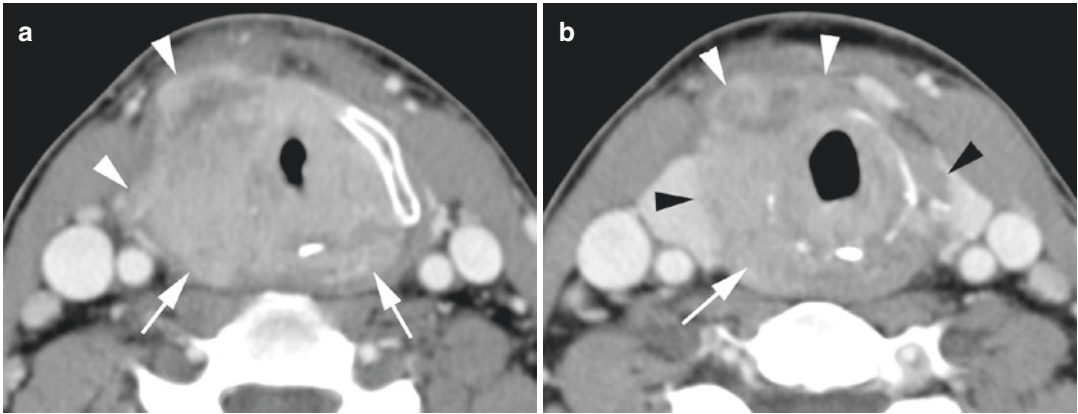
Axial contrast-enhanced CT images in a patient with extensive glottic squamous cell carcinoma. (a) Level of true vocal cords. Circumferential neoplastic involvement of the glottis, with massive destruction of the thyroid cartilage and extralaryngeal spread into the soft tissue anterolateral to the larynx (white arrowheads). Posterior tumor spread into the hypopharynx is at this level visible
